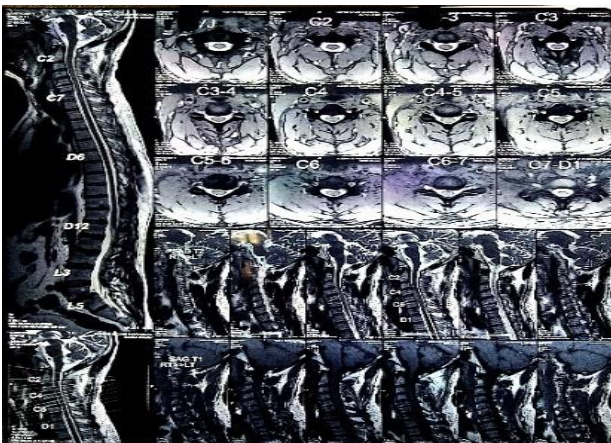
Digital MRI cervical spine with whole spine screening.
